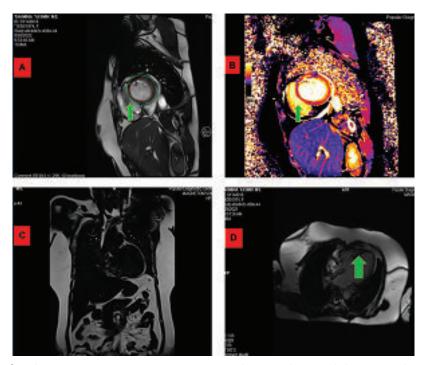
(A,B,C,D): Cardiac magnetic resonance imaging showing late gadolinium enhancement (LGE) of basal interventricular septum ,some part of anterior wall l of the left ventricle, as well as some part of RV.
